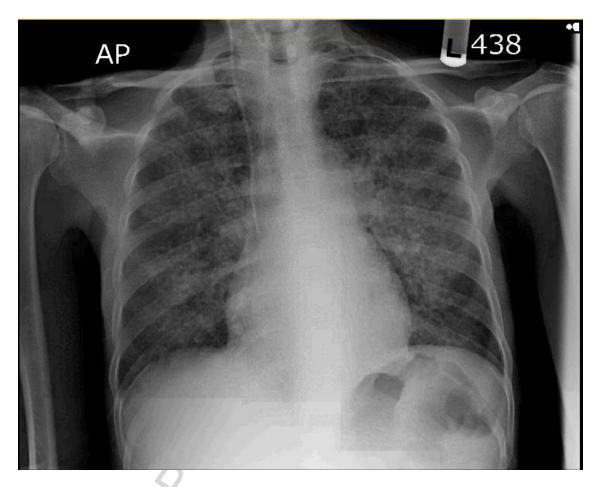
Chest X-ray showing widespread ill-defined opacities
